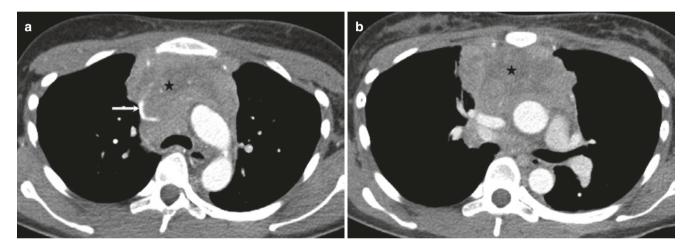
51-year-old woman with superior vena cava syndrome from B-cell lymphoma. (a, b) Axial CT images show large lobulated mass with areas of necrosis compressing the superior vena cava (arrow) and encasing the great arteries
